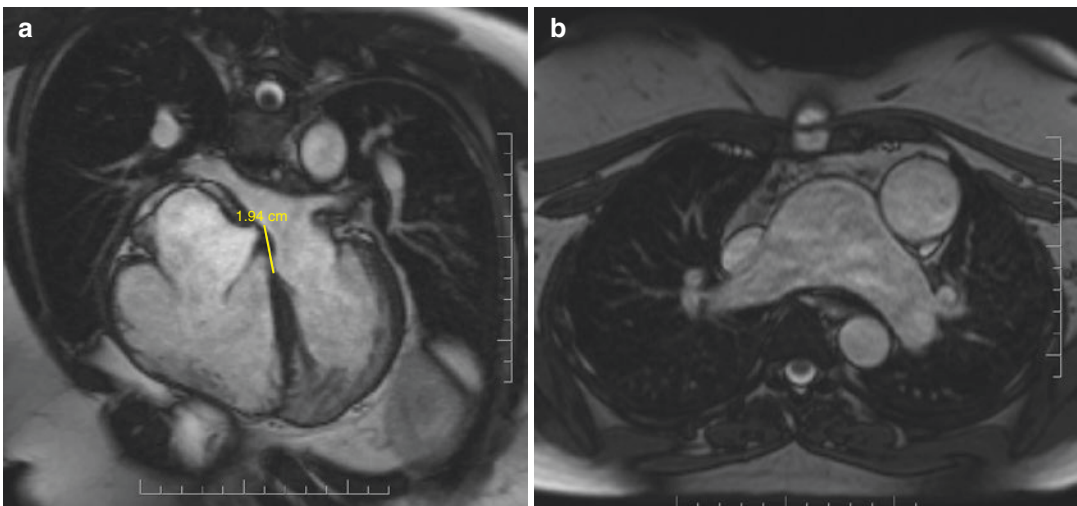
Cardiac magnetic resonance imaging of congenitally corrected transposition of the great arteries with Ebstein-like anomaly of the tricuspid valve (systemic
